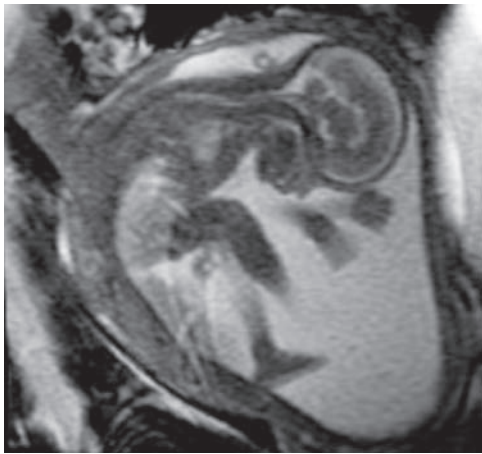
Fetal MR imaging with a FIESTA sequence. Static image shows a fetus in a sagittal orientation. Cine FIESTA sequences of the gravid uterus are used to study fetal movements.
